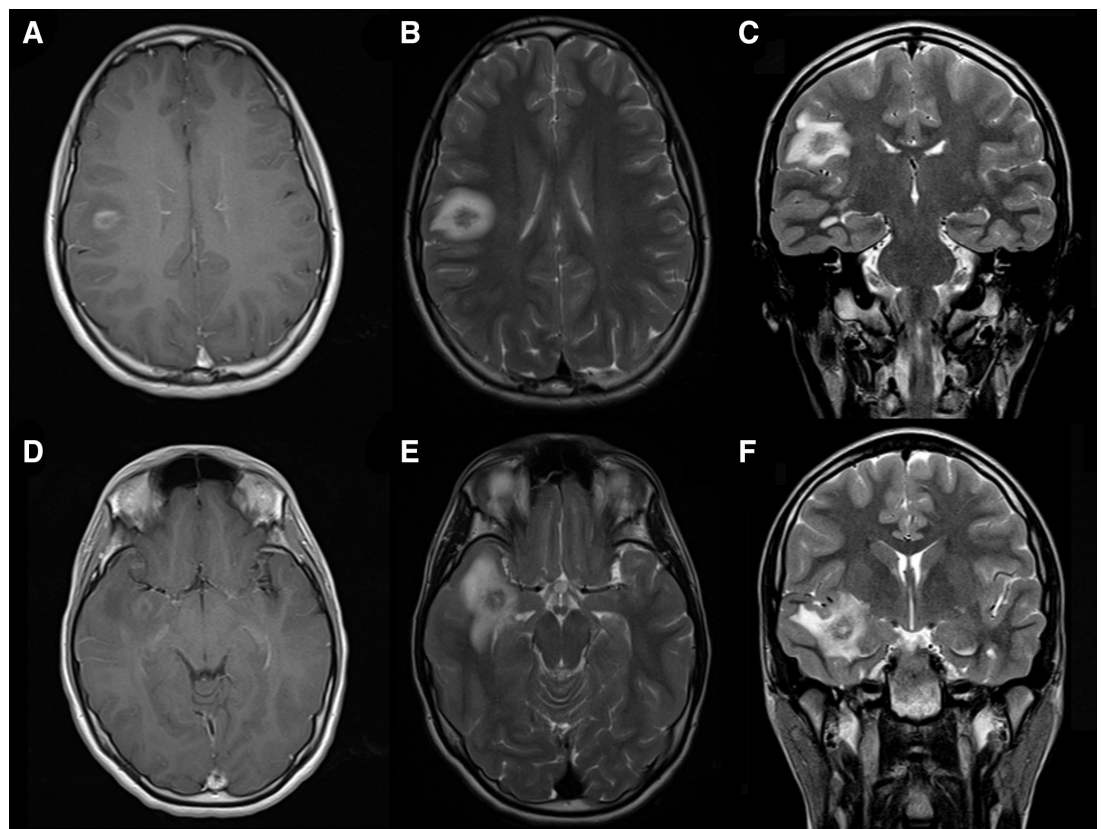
Tumefactive demyelinating lesions: A–C A large subcortical lesion in the posterior-inferior area of the right frontal lobe and D–F A large lesion in the anterior and medial area of the right temporal lobe, with extension to the insular and opercular regions. A, D Axial T1-weighted images after gadolinium injection, with the typical incomplete ring enhancement pattern. B, E Axial T2-weighted images. C, F Coronal T2-weighted images.
